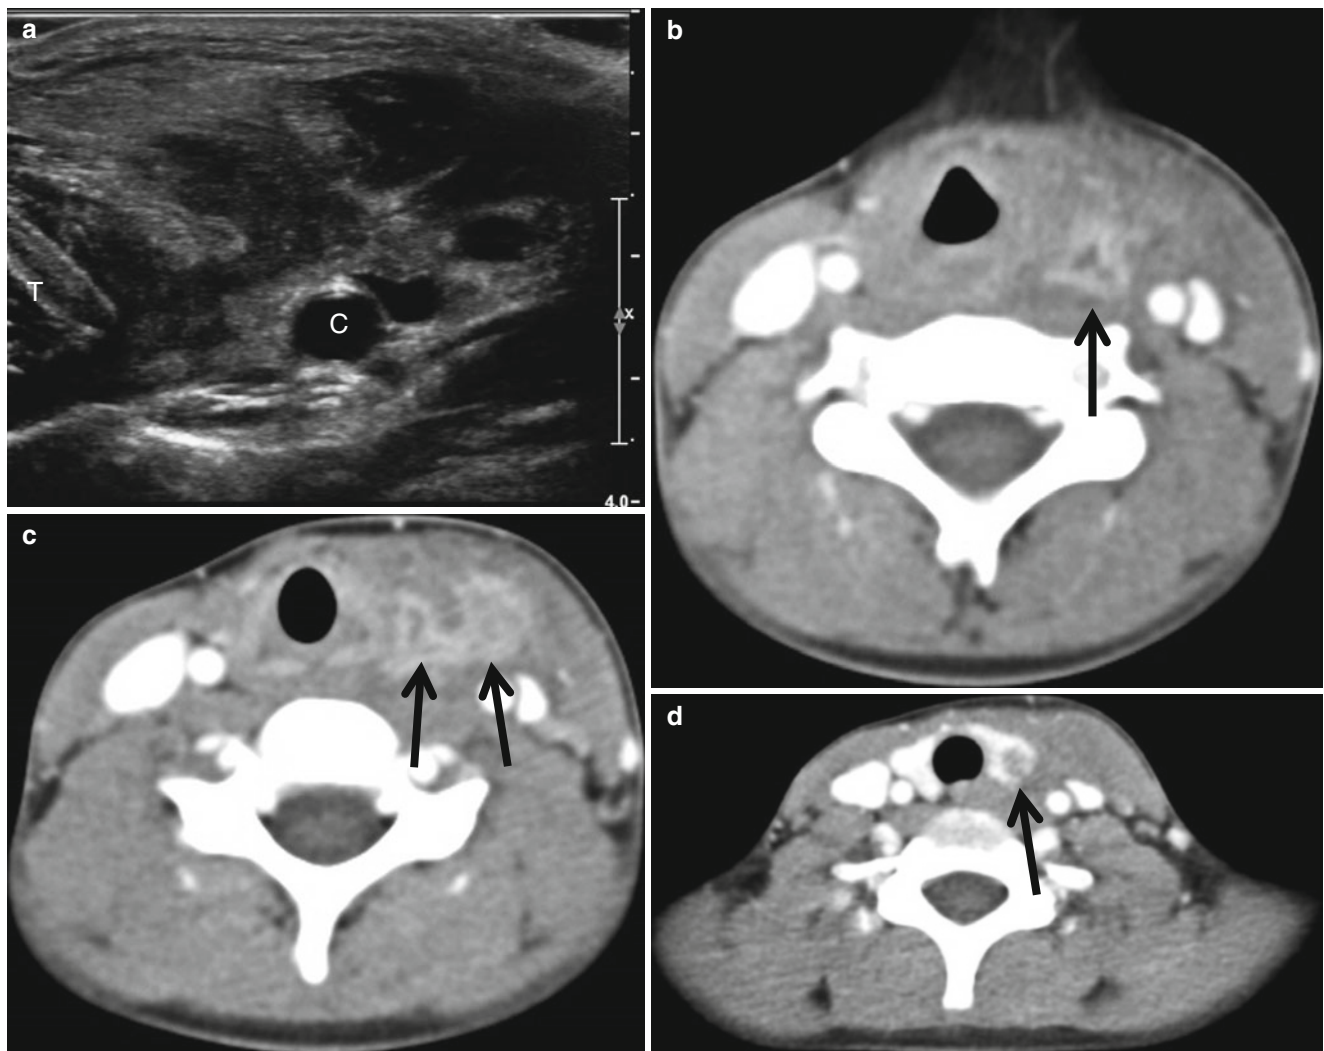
Pyramidal sinus fistula with perithyroiditis in an 8-year-old boy. (a) Ultrasound of the left lower neck shows irregular hypoechoic area in the perithyroidal area extending to the region of pyramidal sinus in keeping with inflammation with almost abscess formation.
